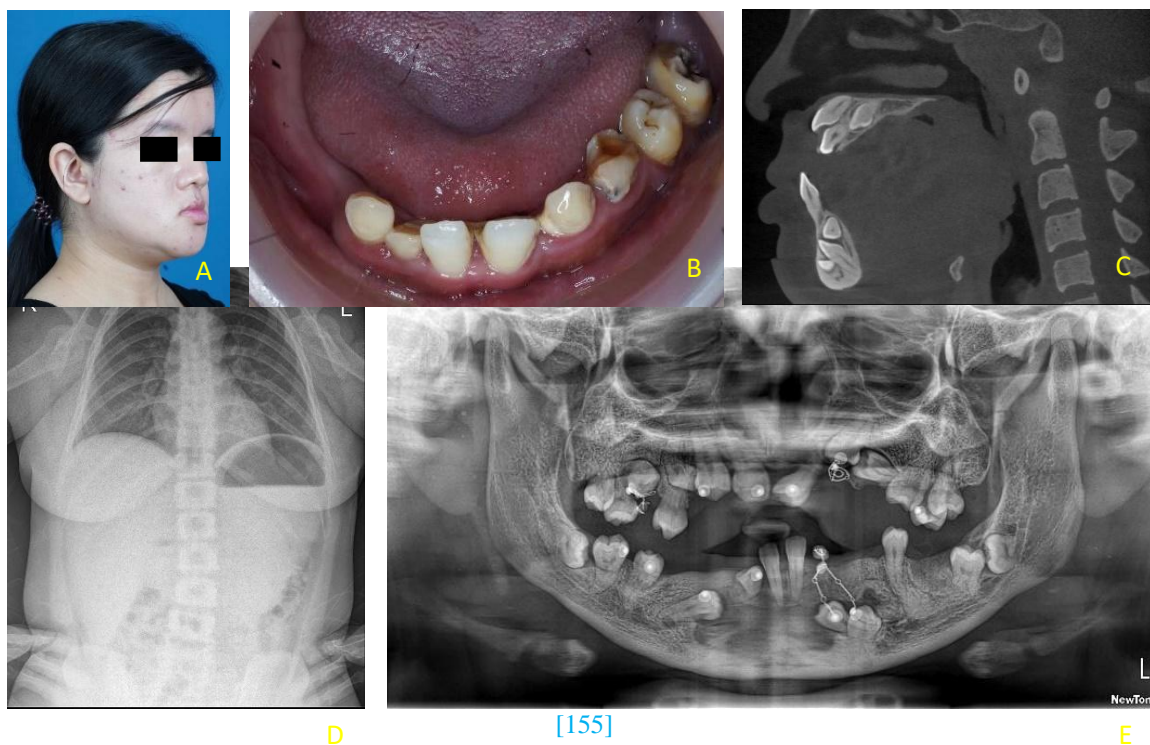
Extra-oral photo showing hypertelorism, frontal bossing, hypoplastic maxilla, and mandibular prognathism (A) ; intra-oral photos showing hypoplastic mandibular edentulous ridge with multiple caries and retained deciduous teeth (B) ; CT scan with multiple unerupted teeth (C) ; chest x-ray showing hypoplastic clavicle, narrow thorax (D) ; and OPG after extractions and placement of orthodontic buttons (E)
